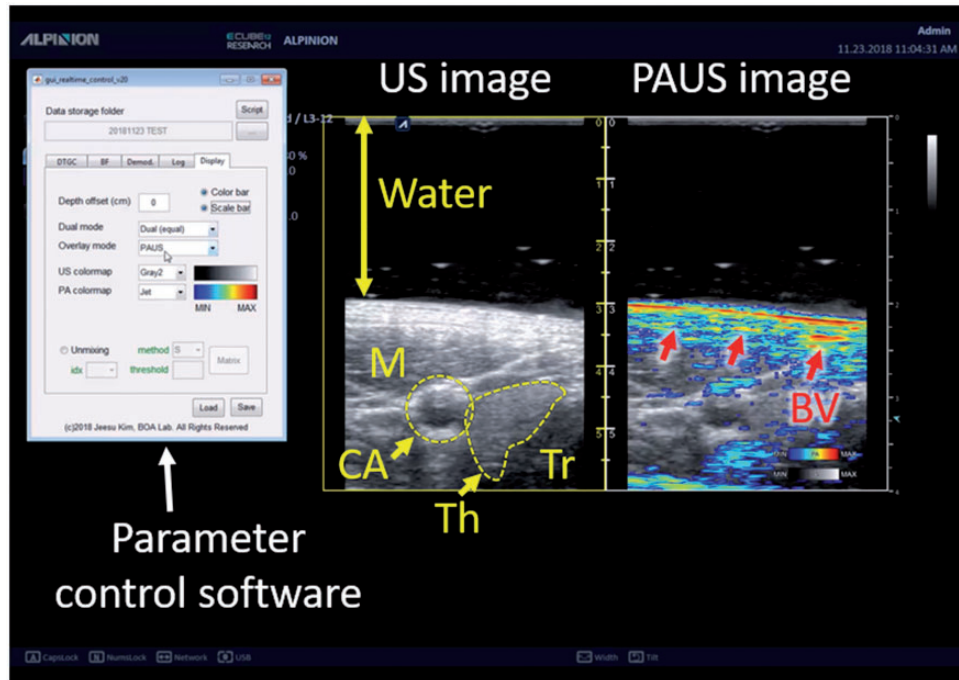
Captured PA and US image from the US machine during real-time imaging of human *in vivo*. PA: photoacoustic; US: ultrasound; M: muscle; CA: carotid artery; Th: thyroid; Tr: Trachea; BV: blood vessel. (A color version of this figure is available in the online journal.)
